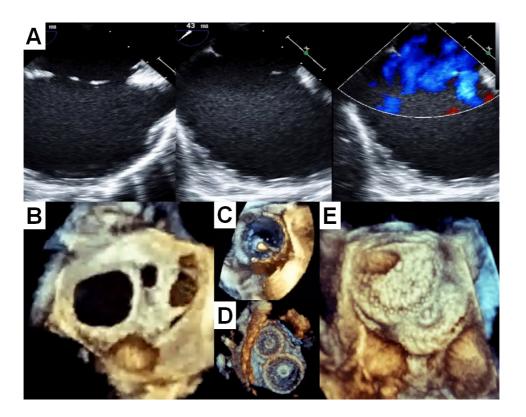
Advantages of real time 3-dimensional (RT3D) transesophageal echocardiography (TEE) guidance in device closure of multiple ASDs.
